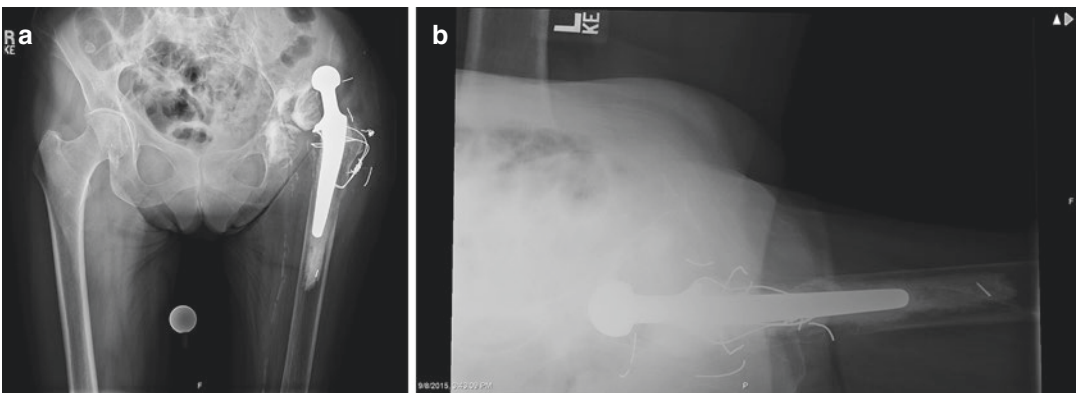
(a, b) AP pelvis and L hip cross-table lateral radiographs taken on initial presentation, demonstrating failure of the left acetabular component with dislocation and superior migration of the femoral head
